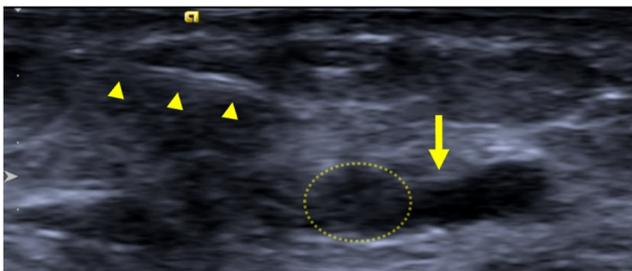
Transverse ultrasound image shows an anechoic defect in the area of the sural nerve after biopsy (*arrow*). The adjacent small saphenous vein appears intact (*dashed circle*). The needle introducer is seen more superficially (*arrowheads*)
